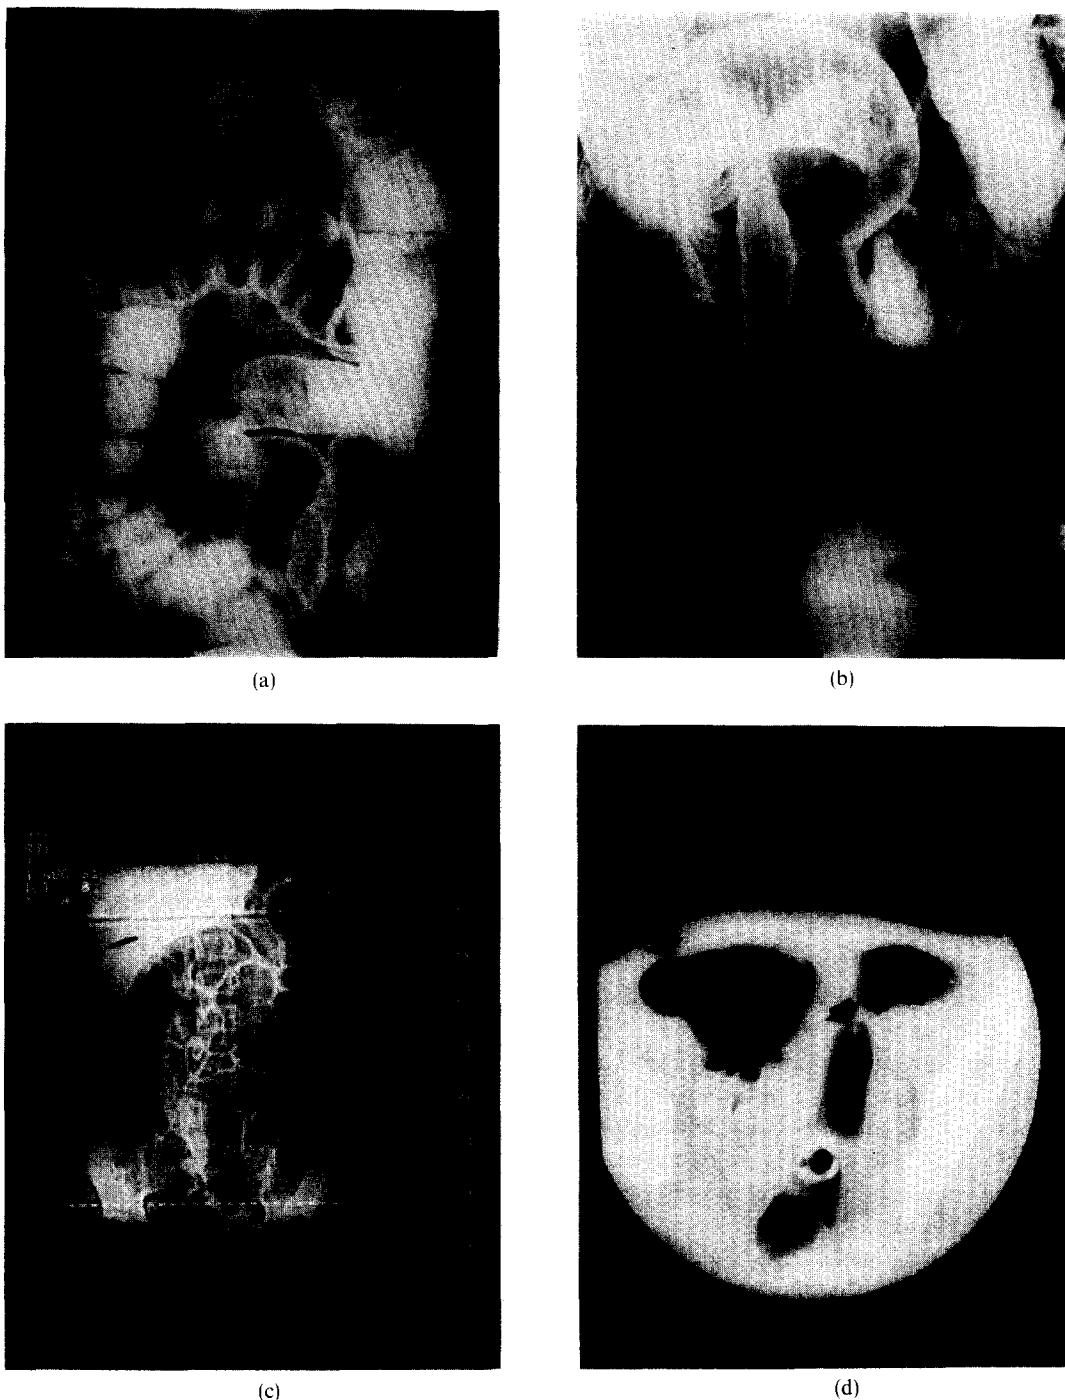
Case 1: conventional air contrast barium enema (a,b) shows small filling defects in the sigmoid colon (arrows). Digital radiograph (c) outlines the colon distended with air. White line indicates the level of CT section (d). Multiple small polyps are demonstrated (arrows).
